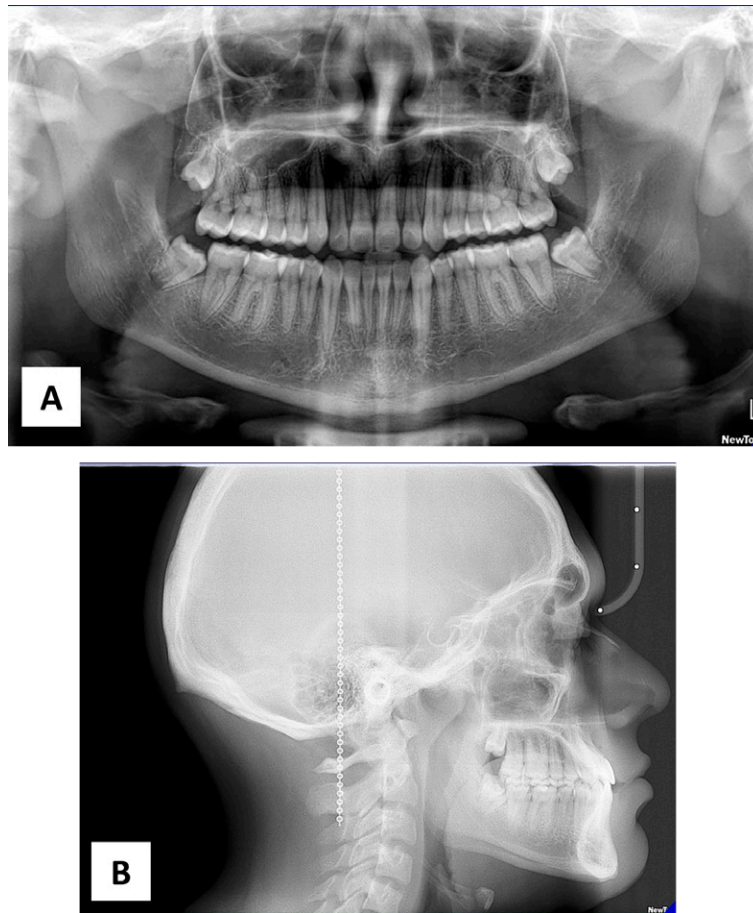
Final radiographic images. A. Orthopantomography. B. Lateral headfilm.
